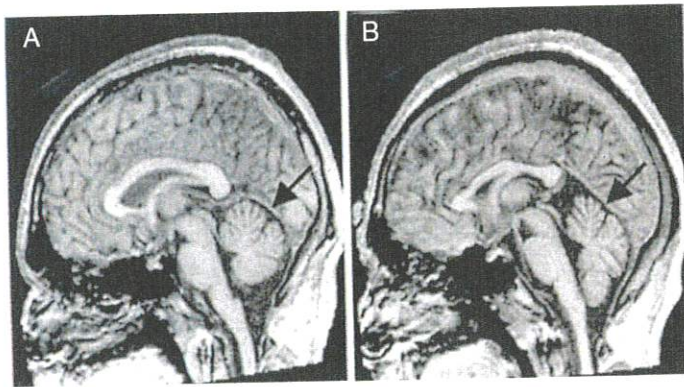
MRI SCANS FROM THE CEREBELLAR AREAS OF A 16-YEAR-OLD BOY WITH AUTISM (A) AND A 16-YEAR-OLD BOY WITHOUT AUTISM (B). Note the somewhat smaller cerebellar area in the youth with autism, which may contribute to abnormal motor movements and cognitive impairments often seen in people with autism. From Palmen, J.M.C., van Engeland, H., Hof, P.R., & Schmitz, C. 2004. Neuropathological findings in autism. *Brain*, 127, 2572-2583.
